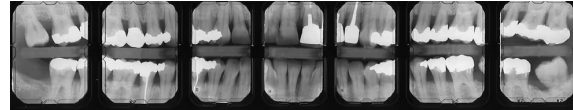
Anterior and Posterior Vertical Bitewing Survey
